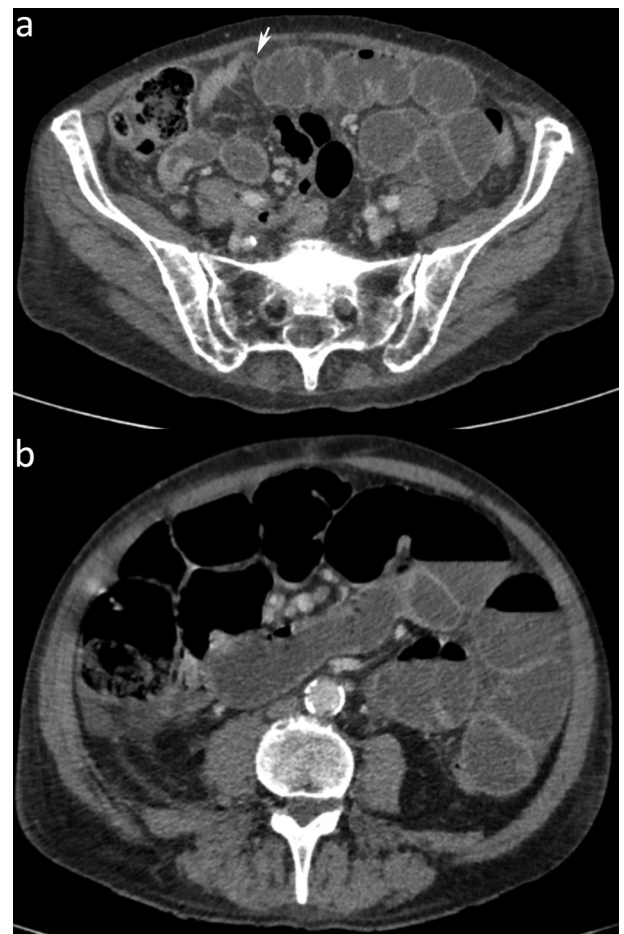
a) Abdominal CT scan in a patient with small bowel obstruction demonstrating transition (arrow) between dilated small bowel proximal to the obstruction and collapsed bowel distally. b) Abdominal CT scan in a patient with postoperative ileus demonstrating fluid and air filled dilated bowel loops without a transition point.
